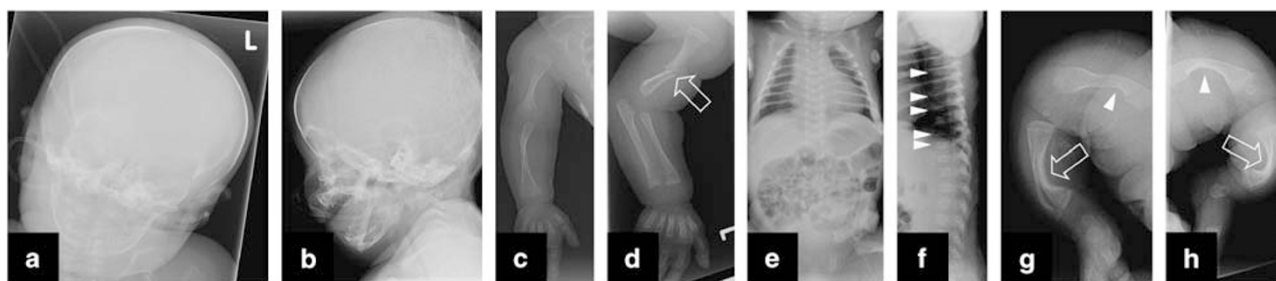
Radiographs of individual VI:5 from family 1. (a) Apparent normal mineralization of the skull, no Wormian bones. (b) Mild brachycephaly. (c) Normal aspect of the right arm. A rhizomelic shortening may exist that may also be because of projection, given the normal length of the left humerus. (d) Oblique mid diaphyseal fracture of left humerus (arrow). (e) Normal chest radiograph without rib fractures. (f) Platyspondyly of thoracic vertebrae, 5, 7, 8, 10 and 11 (arrowheads). (g) Bowing of femora (arrowhead), tibiae and fibulae (arrow). (h) Bowing of femora (arrowhead), tibiae and fibulae (arrow).
